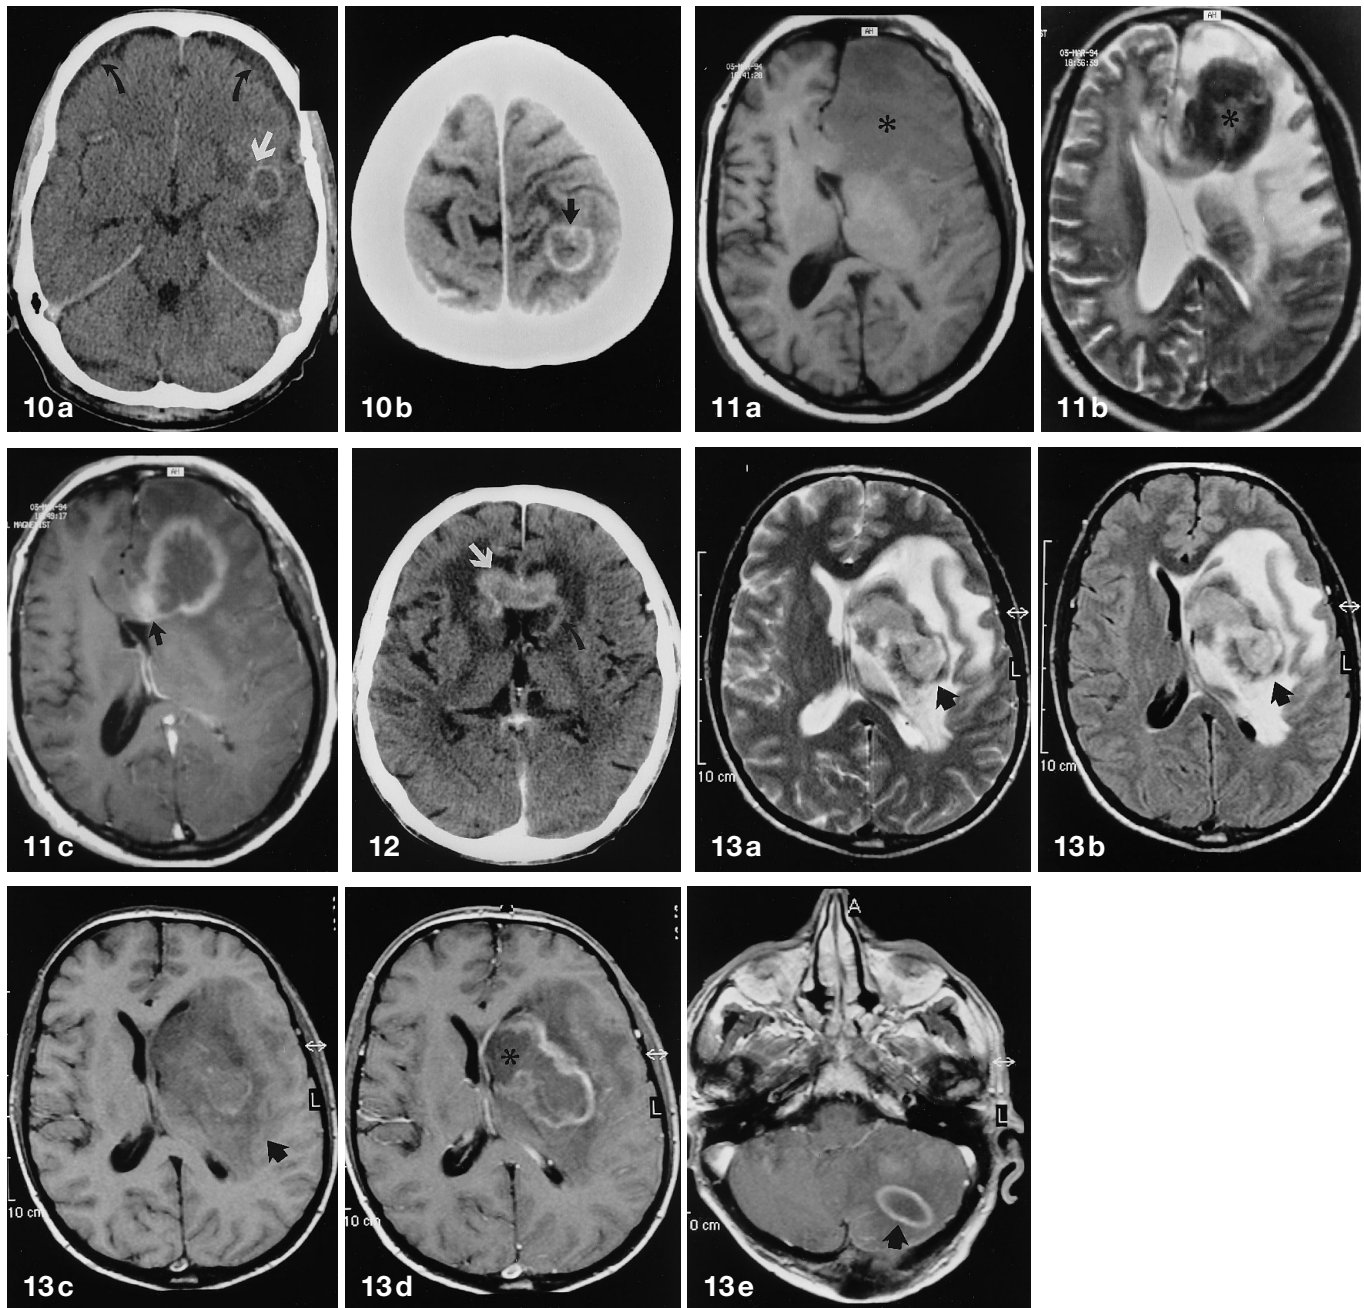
a, b. Invasive aspergillosis. a Contrast-enhanced CT scan in a 44-year-old AIDS patient who presented with cognitive impairment and hemiparesis shows ring-like enhancing lesion (*white arrow*) with moderate adjacent edema in the left insular region, and bilateral frontal subdural hygroma (*black arrows*). b At a higher level, additional cortical ring-enhancing lesion (*arrow*) is shown in the left parietal lobe. Brain biopsy revealed diagnosis of disseminated necrotic encephalitis due to aspergillosis
